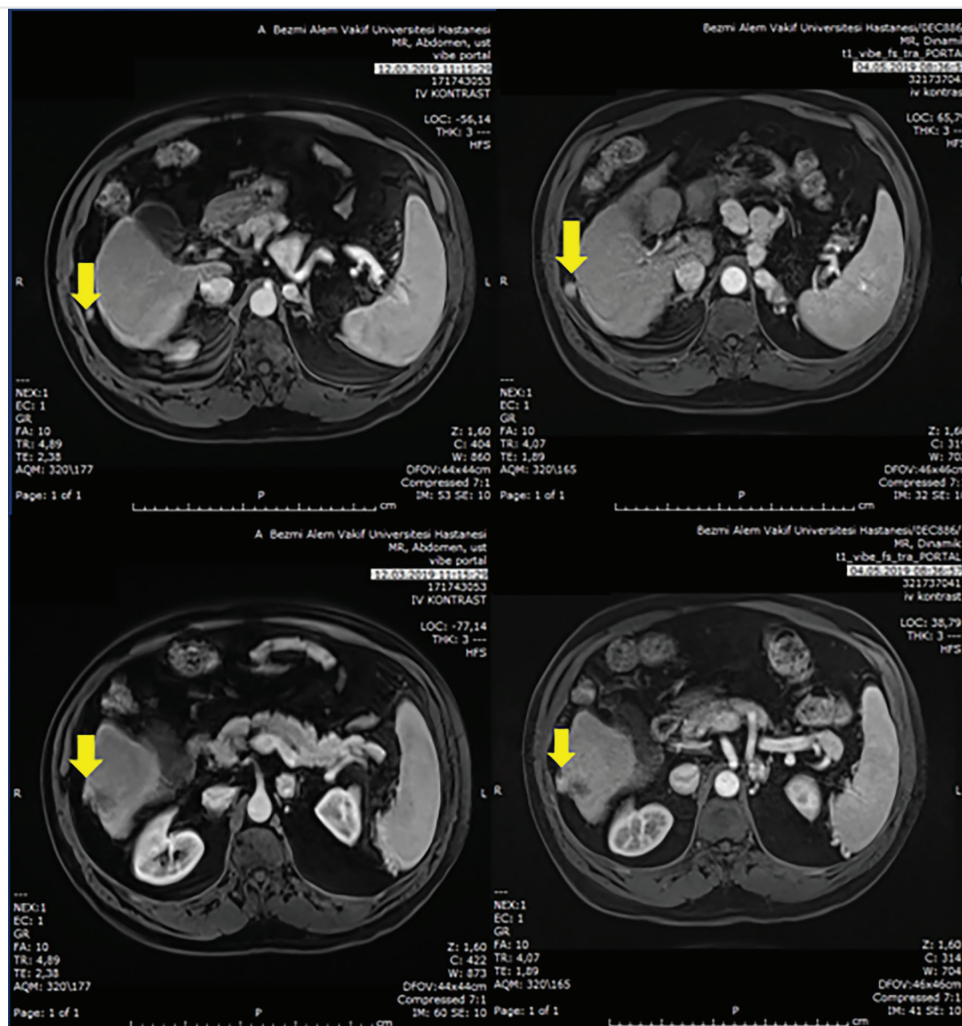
Follow-up magnetic resonance imaging showing newly developed nodular lesions adjacent to the radiofrequency ablation zone: a 10 mm nodule on the capsular surface and an 11 mm lesion within the adjacent adipose tissue, suggestive of neoplastic tract seeding
